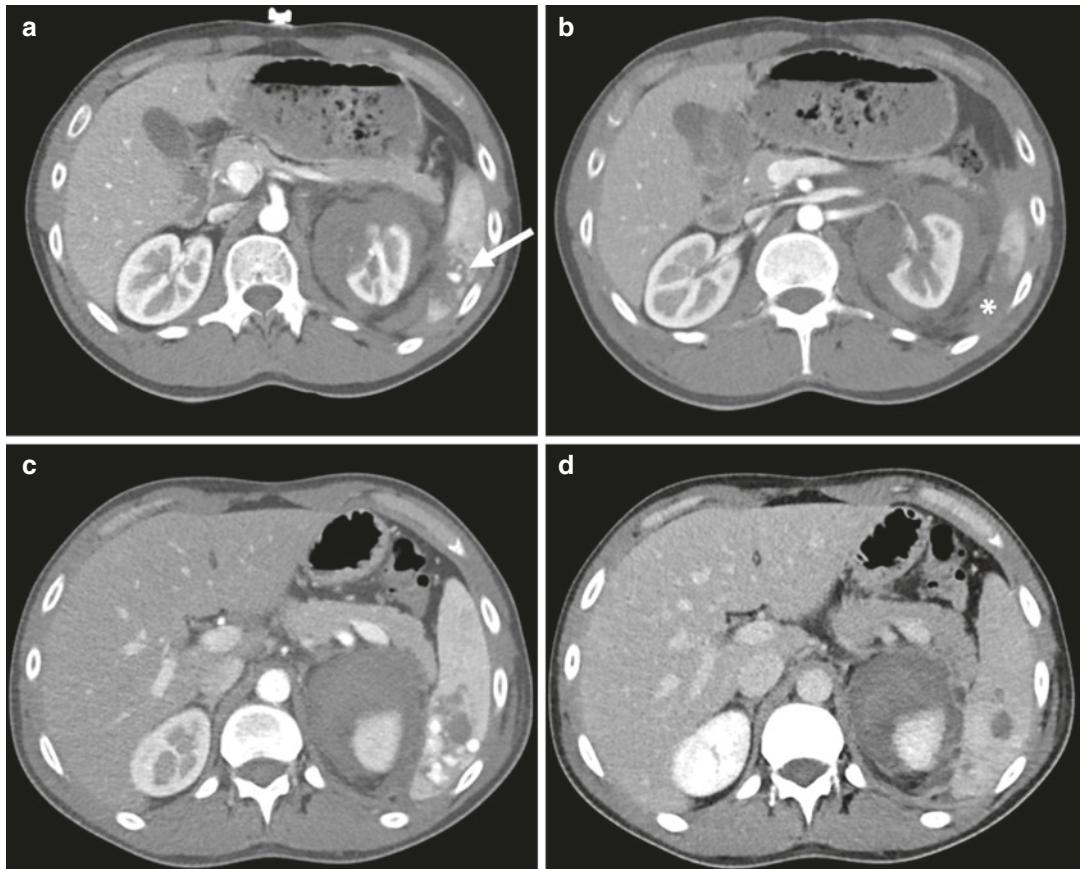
A 28-year-old man was admitted to the emergency department following motor vehicle collision. Two contiguous axial contrast-enhanced CT images (a, b) demonstrate deep lacerations in the left kidney with perirenal hematoma (grade 3 according to AAST) and a pseudoaneurysm in the spleen (A, arrow), with an adjacent small amount of hemoperitoneum (b, asterisk). Both findings were initially treated non-operatively. Follow-up CT
